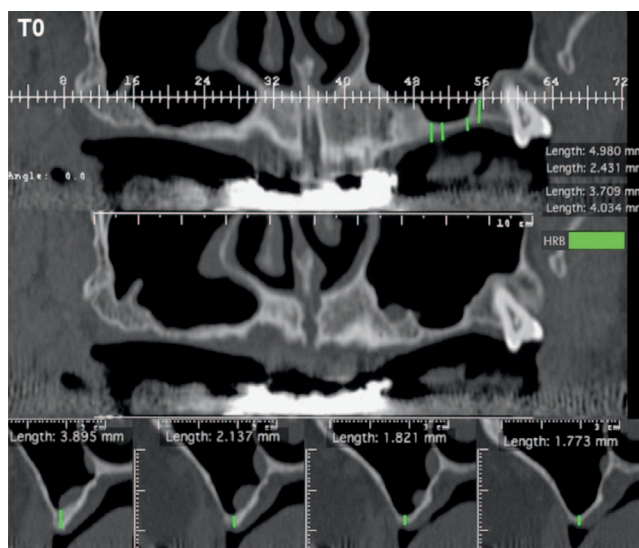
Example of radiographic measures at T0 on cone-beam computerized tomography. Light green: height of residual bone before sinus surgery (HRB).
